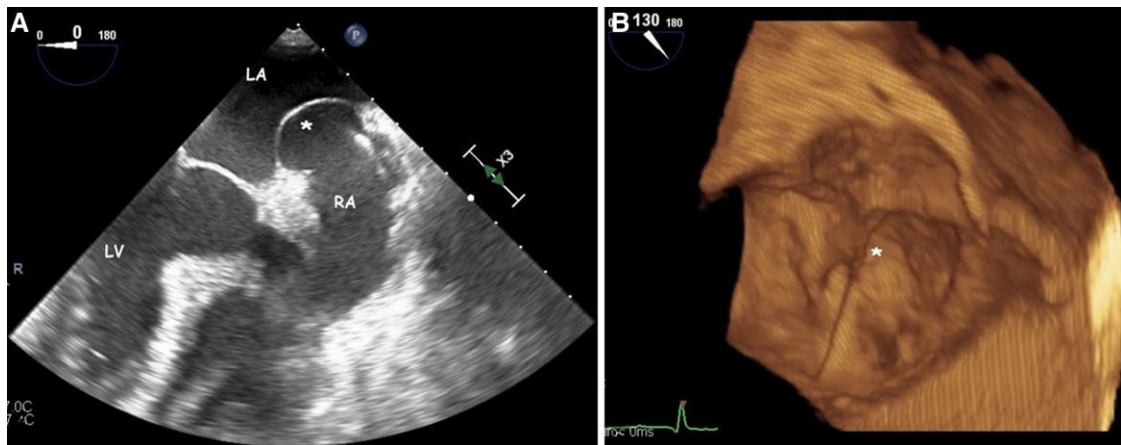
Thin, hyper-mobile ASA (asterisk) as imaged at 2D (A) and 3D (B) TEE echocardiography. LA, left atrium; LV, left ventricle; RA, right atrium.
